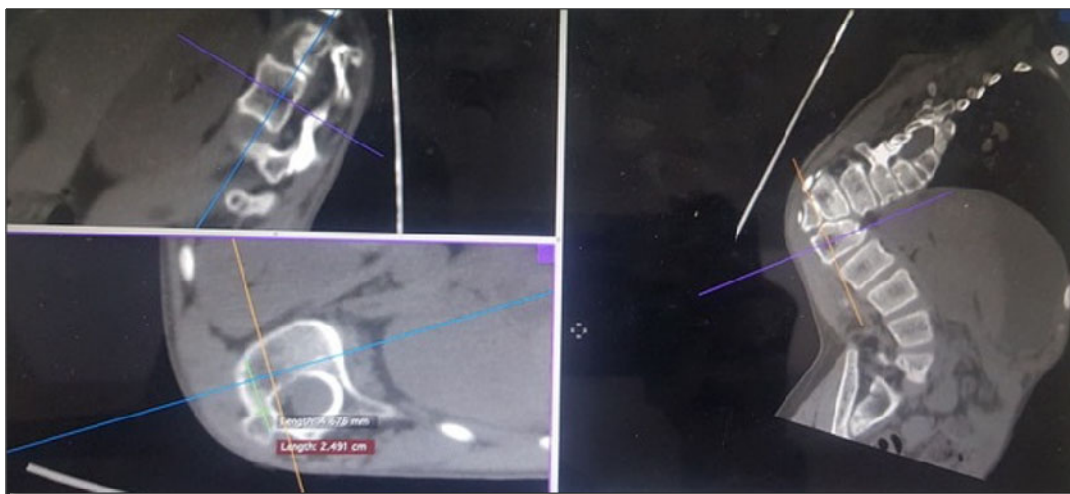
Measurement of degree of rotational deformity of vertebral column using preoperative CT scans of spine.
